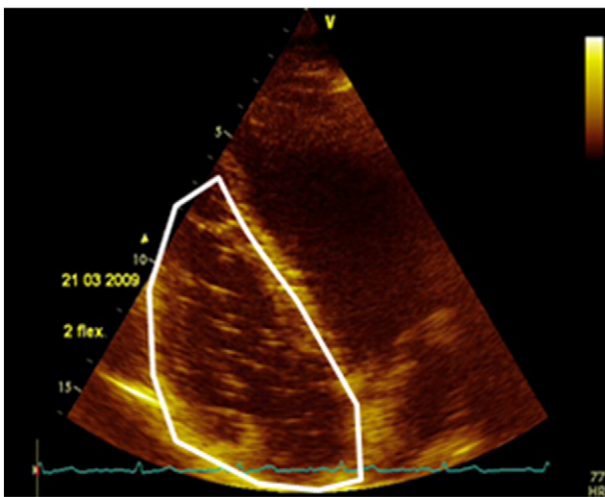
Ultrasound imaging of the heart 1 h post scuba dive. Venous gas emboli (VGE) are circulating in the right heart chambers (delineated in white, image reversed). The lungs are effectively filtering these VGE and they do not appear in the left heart chambers.
